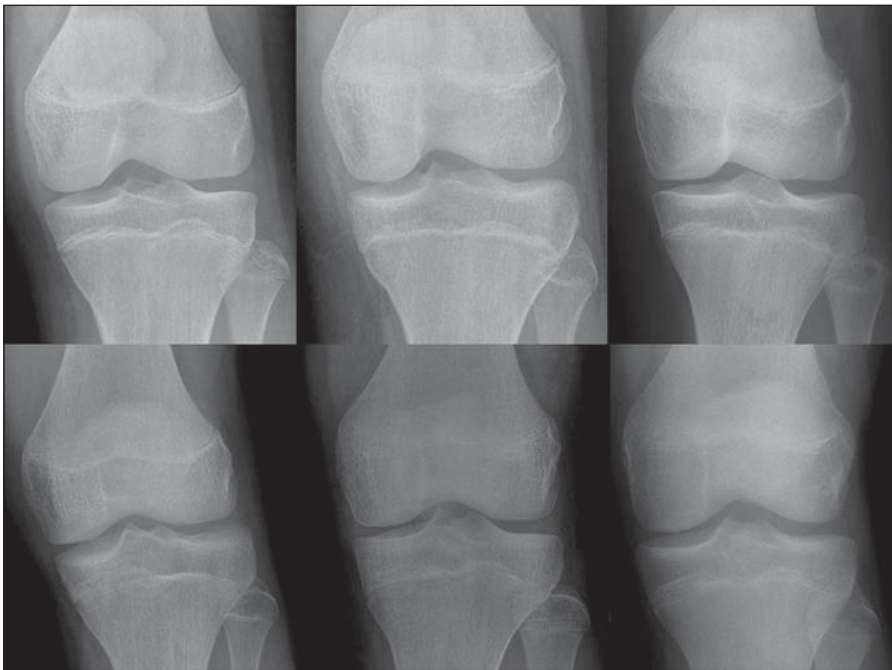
Frontal knee radiographs (uniformly projected to allow comparison) of three girls (top row) ranging in age from 11 years 11 months to 14 years 4 months and three boys (bottom row) ranging in age from 13 years 8 months to 15 years 4 months. All had FOPE (focal periphyseal edema pattern) zones identified on knee MRI examinations. There is striking similarity in degree of skeletal maturation and extent of physeal closure in all patients both within and between sexes.
